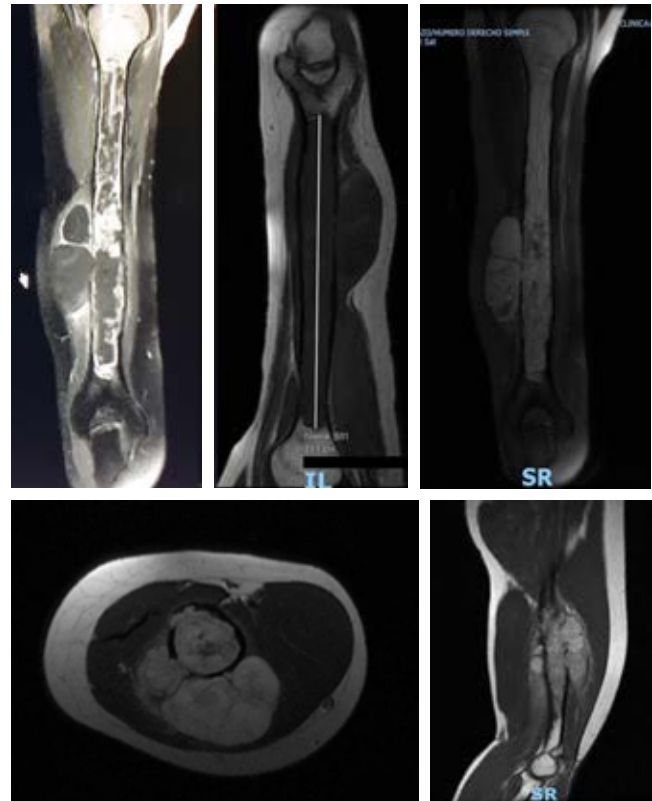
Different magnetic resonance imaging views showing complete diaphyseal involvement with extensive bone lysis and soft tissue involvement.
